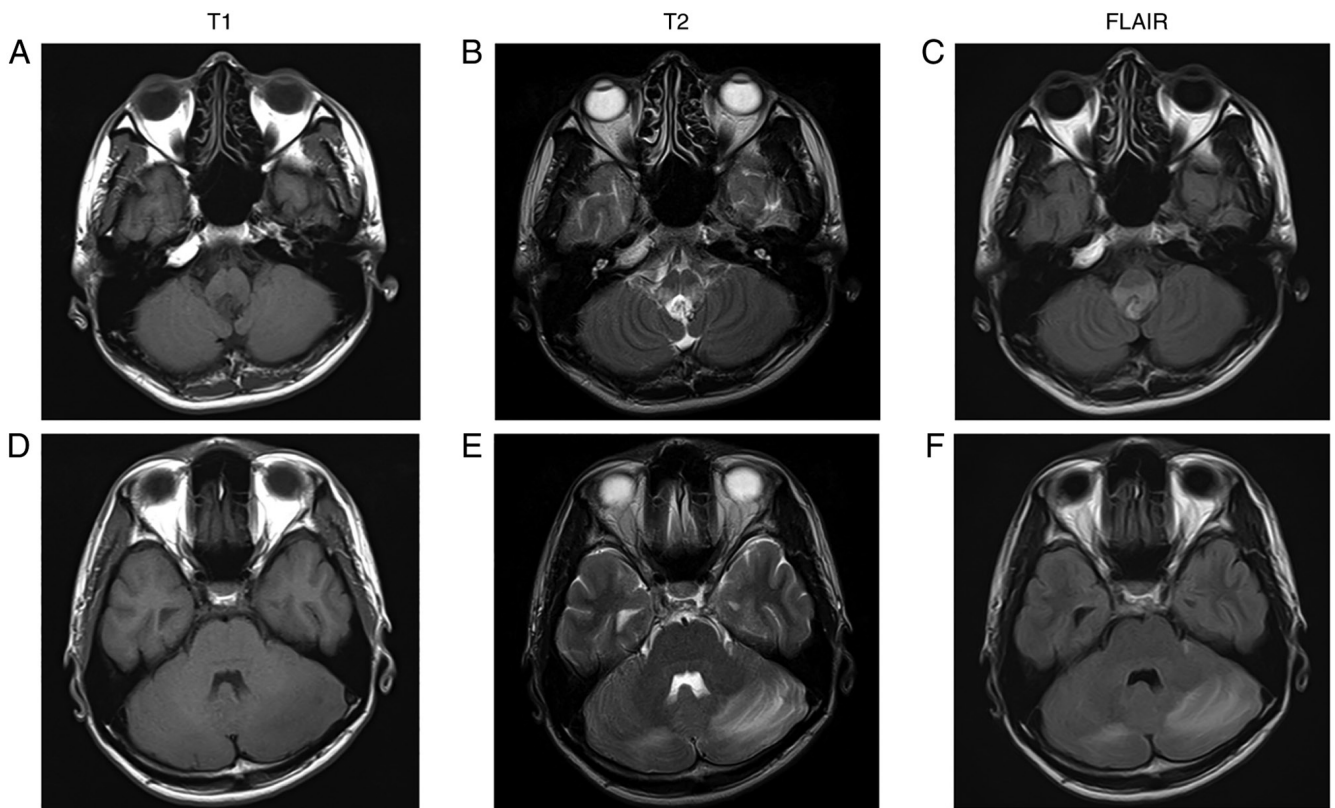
Preoperative non-contrast magnetic resonance imaging. Axial views showed a mass in the dorsal medulla oblongata [(A) T1-weighted imaging, (B) T2-weighted imaging and (C) FLAIR] and bilateral cerebellar edema [(D) T1-weighted imaging, (E) T2-weighted imaging and (F) FLAIR]. FLAIR, fluid attenuated inversion recovery.
